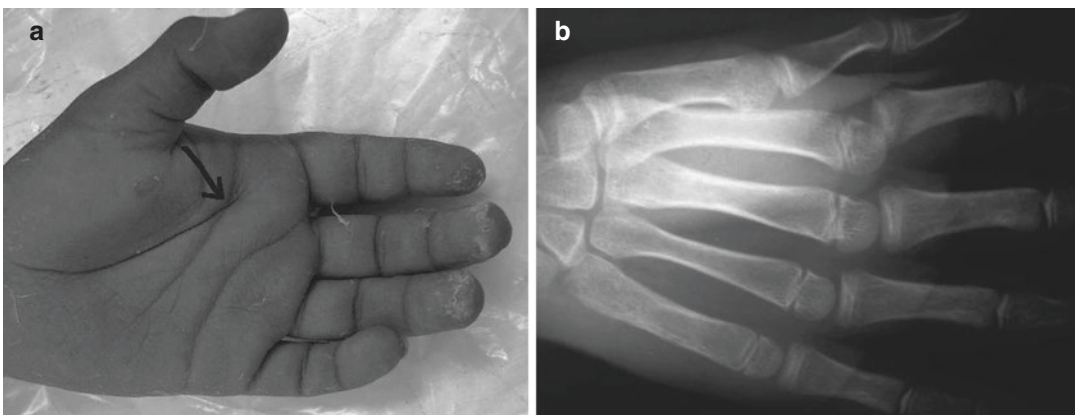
Complex index MC dislocation. (a) Arrow points to characteristic palmar pucker. (b) X-ray showing index MCP incongruity
